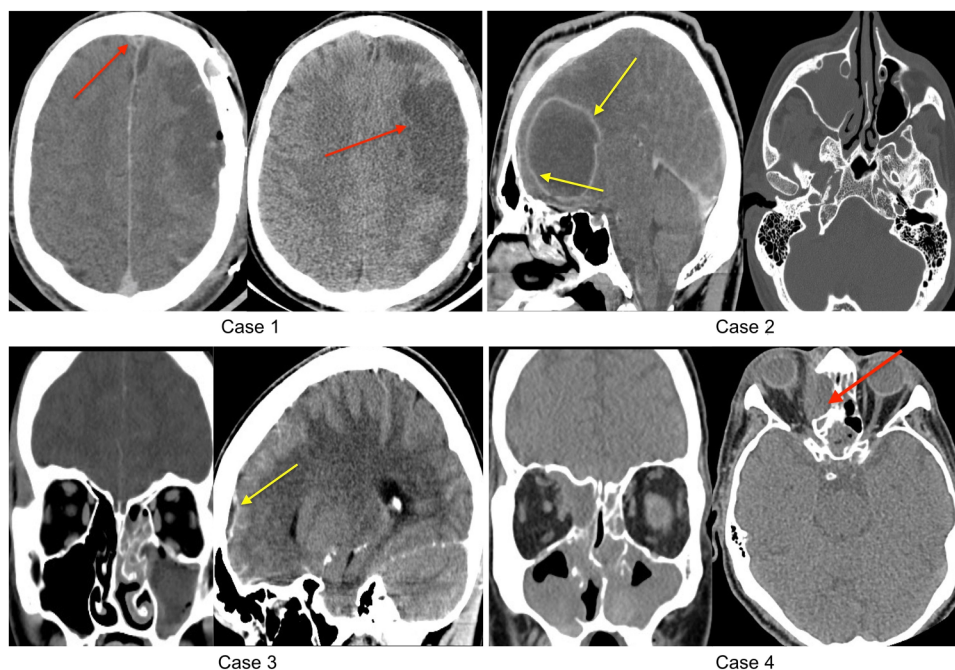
Case 1: axial CT show superior sagittal sinus thrombosis + subdural empyema. Case 2: sagittal CT shows intracranial abscess, axial CT shows isolated right-side maxillary sinusitis. Case 3: sagittal CT shows epidural abscess, Coronal CT shows left-side pansinusitis. Case 4: axial CT shows right-side intra-orbital abscess, Coronal CT shows bilateral pansinusitis.
